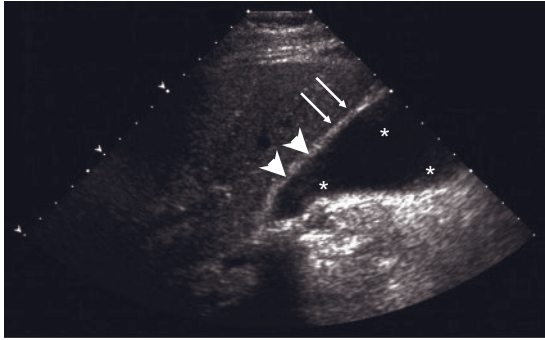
Ultrasound image of cholecystitis of the gall bladder demonstrates several small gall stones (asterisks). The gall-bladder wall is slightly thickened (arrowheads), with some fluid in the wall (arrows). These findings are consistent with acute cholecystitis. (Courtesy of MD Patel, MD, Department of Radiology, Mayo Clinic Arizona.)
